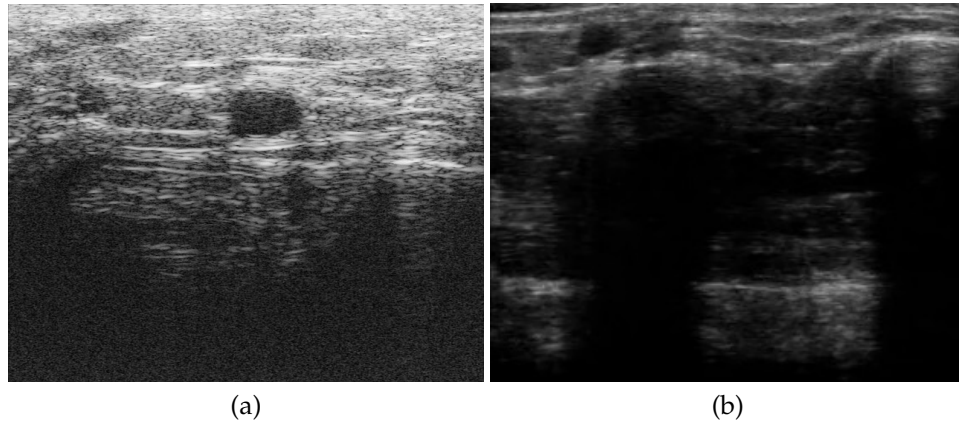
(a) Example UHFUS image of the proper palmar digital artery in the hand. Image obtained with a 50 MHz ultrasound probe (b) Example HFUS image of the same vessel obtained with a 22 MHz ultrasound probe. In contrast to the HFUS image, note the higher resolution and increased speckle noise in the UHFUS image.
